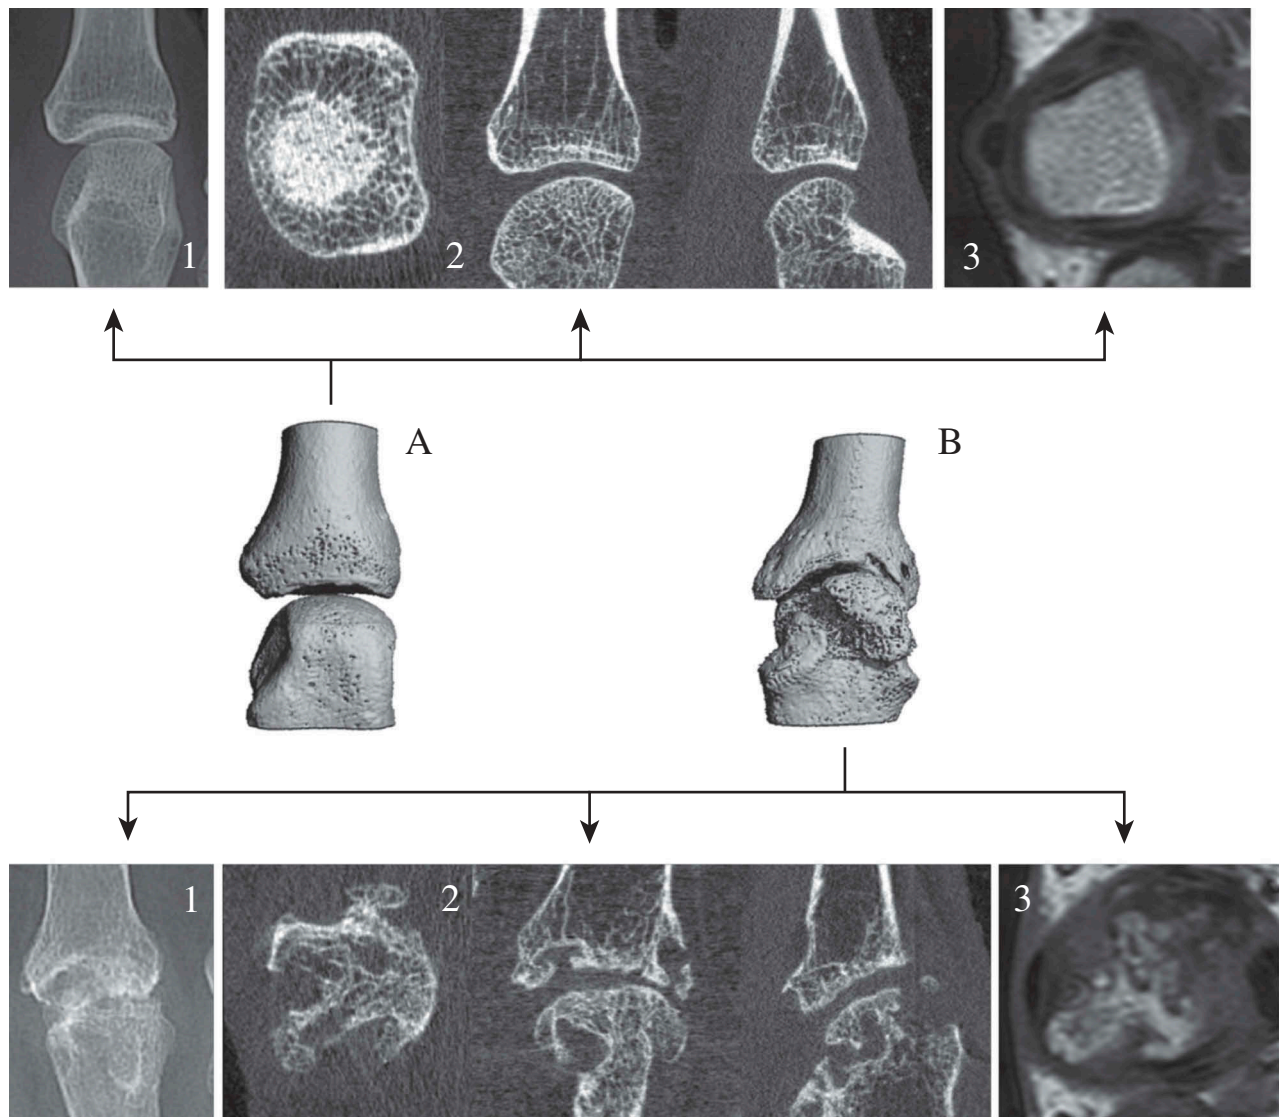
Two examples of metacarpophalangeal (MCP) joints. Example A: An MCP joint in a healthy subject with corresponding radiograph; axial, coronal, and sagittal high-resolution peripheral quantitative computed tomography (HR-pQCT) images; and magnetic resonance imaging (MRI) image. Example B: A totally destroyed joint in a patient with rheumatoid arthritis with corresponding radiograph; axial, coronal, and sagittal HR-pQCT images; and MRI image. Same subject as in Figure 1, panel 2.
